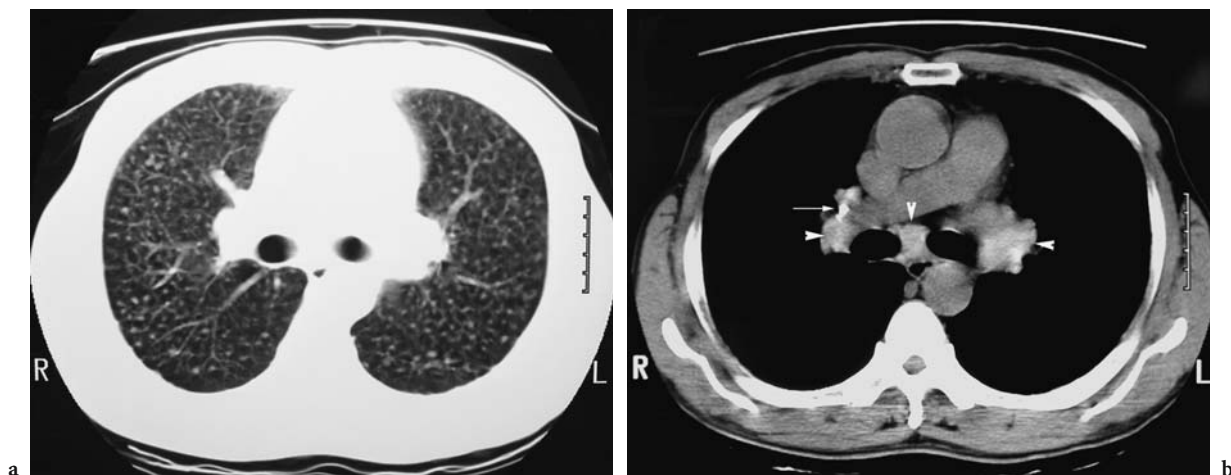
A 56-year-old tunnel blaster with simple silicosis and lung cancer who was evaluated with multi-slice computed tomography (CT) scan of the thorax (2.5-mm slice thickness) with retrospective reconstruction into 1.25-mm thin-section CT scans. a CT scan (2.5-mm thickness) shows small centrilobular nodules in both lungs, with an irregular mass in the superior left hilum. b Thin-section CT scan (1.25-mm thickness) at the same level as a was reconstructed from the multi-detector CT data set. c CT scan (2.5-mm thickness) in mediastinal window shows enlarged mediastinal lymph nodes with dense (arrowheads) and eggshell (arrows) calcification
